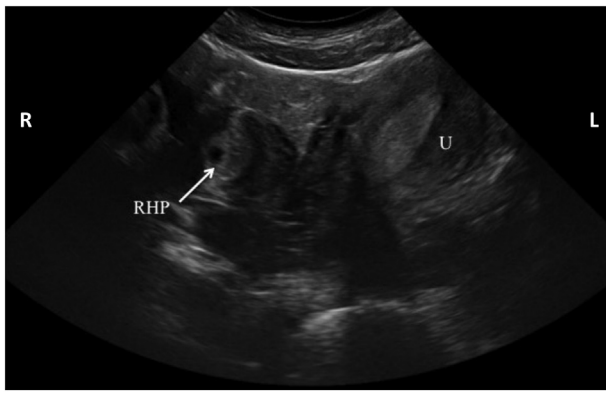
The transabdominal sonogram shows the left-sided uterus and the rudimentary horn with the yolk sac on the right (arrow). U uterus, RHP rudimentary horn pregnancy.
